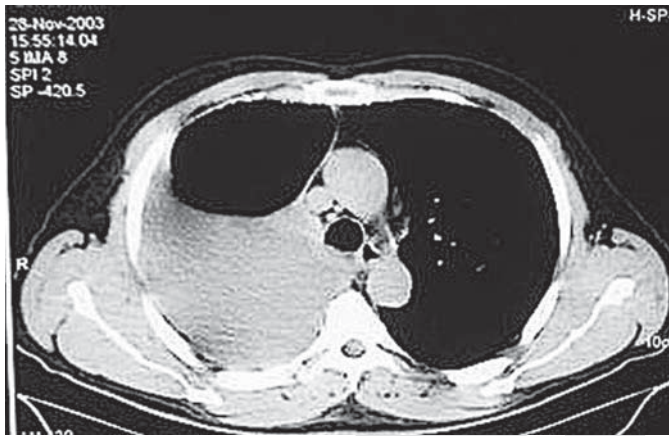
Patient's chest computed tomography upon diagnosis in November 2003.
